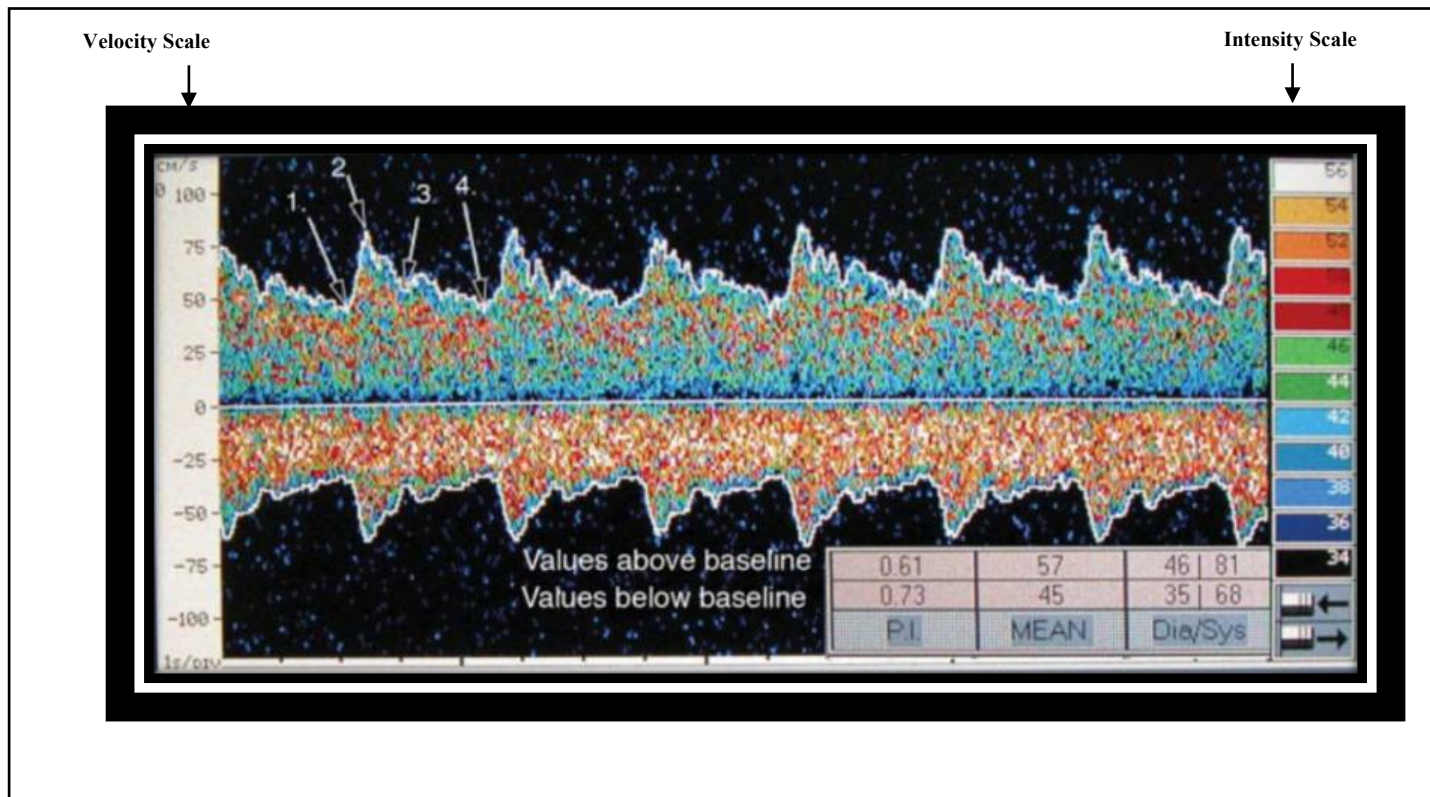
Transcranial Doppler (TCD) sonogram, adapted from (352).
